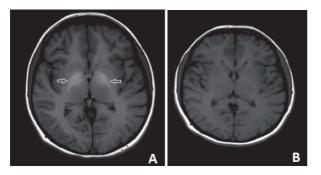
Basal Ganglia Increased Intensity in TI-Weight Magnetic Resonance Images
